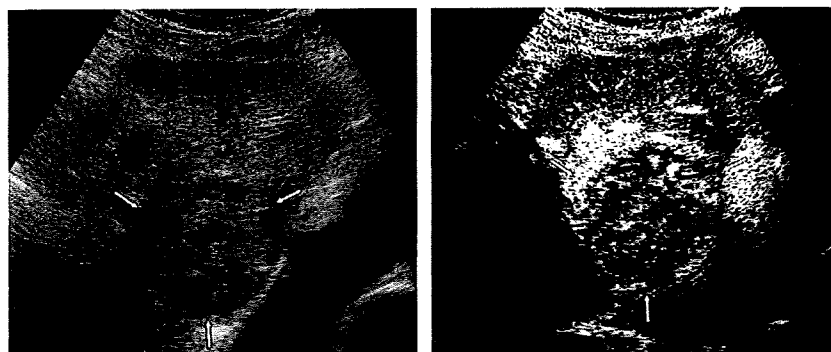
A 75-year-old man with hepatitis C cirrhosis and hepatocellular carcinoma (*arrows*). (a) Oblique subcostal left-lobe B-mode ultrasound shows mosaic mass (*arrows*). (b) In the arterial phase, lesion (*arrows*) shows diffuse heterogeneous and slightly hypovascularity relative to liver parenchyma. Percutaneous biopsy revealed poorly differentiated hepatocellular carcinoma.
